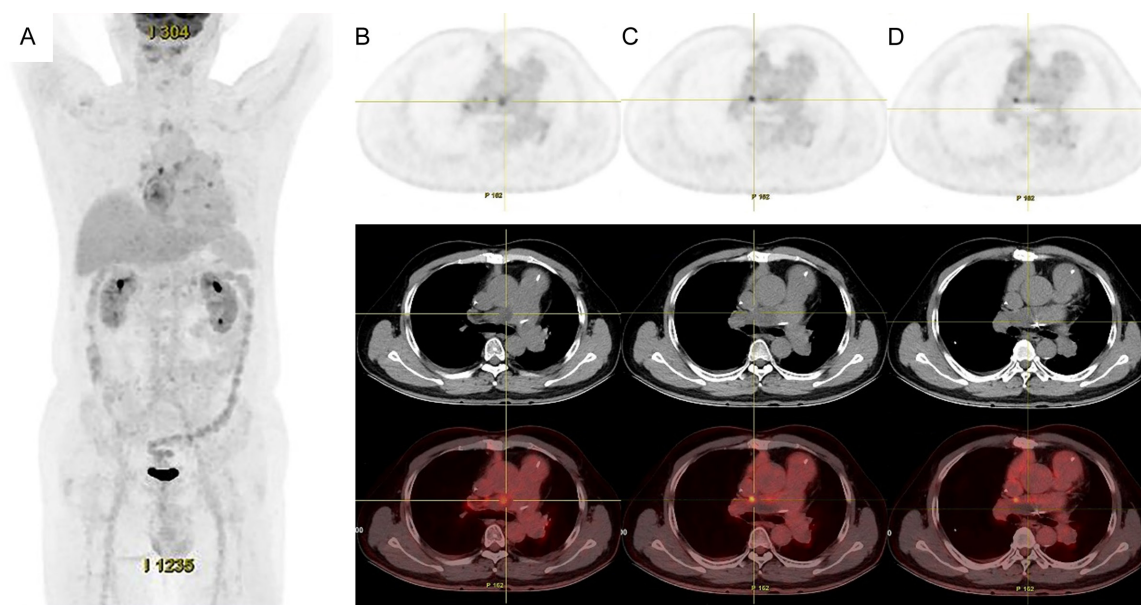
^{18}F -FDG PET/CT images 2 months after treatment with ^{125}I -seeds implantation. A. The anteroposterior 3-dimensional maximum intensity projection image (MIP) demonstrated a hypermetabolic lesion in the right pulmonary artery trunk while no abnormal FDG metabolism was found in other parts of the body; B, C. Nodular lesion in the right pulmonary artery wall, with an increased FDG uptake (SUVmax = 7.6); D. A radiological defect in the right pulmonary artery trunk is seen in the form of a striped hypodense lesion with a CT attenuation value of approximately 32 HU.
